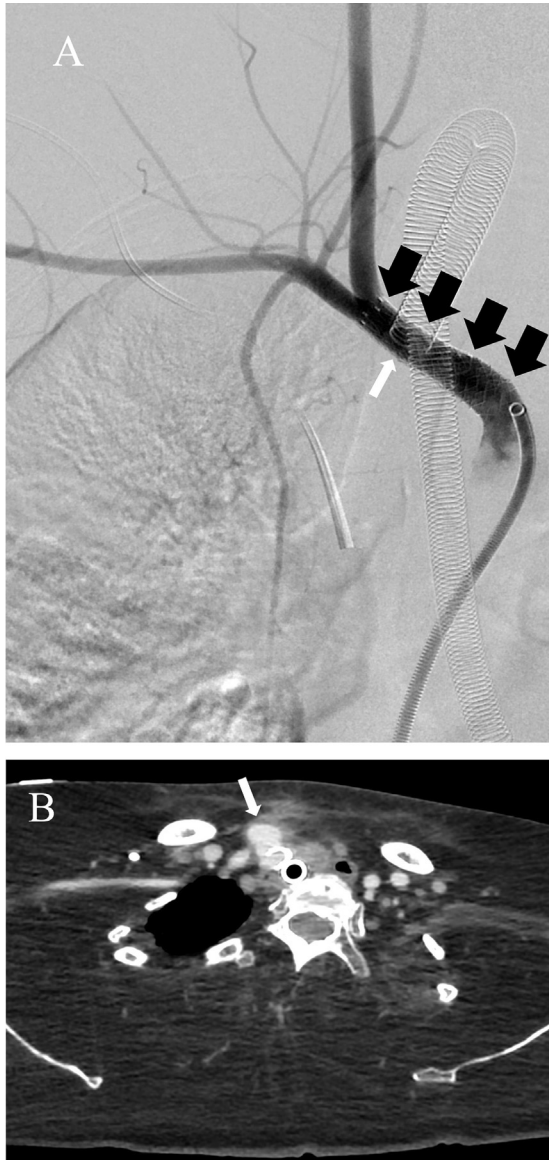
(A) 8 × 25 mm (black arrows) and 8 × 29 mm VBX (black arrows) Viabahn stent-grafts were placed at the brachiocephalic artery to seal the tracheo-innominate artery fistula (white arrow). (B) Contrast-enhanced computed tomography (CECT) image obtained 26 months after placement of a stent-graft revealed a pseudoaneurysm (white arrow) with periarterial soft tissue thickening and surrounding fat stranding at the distal edge side of the stent-graft, which was at the origin of the right subclavian artery.
